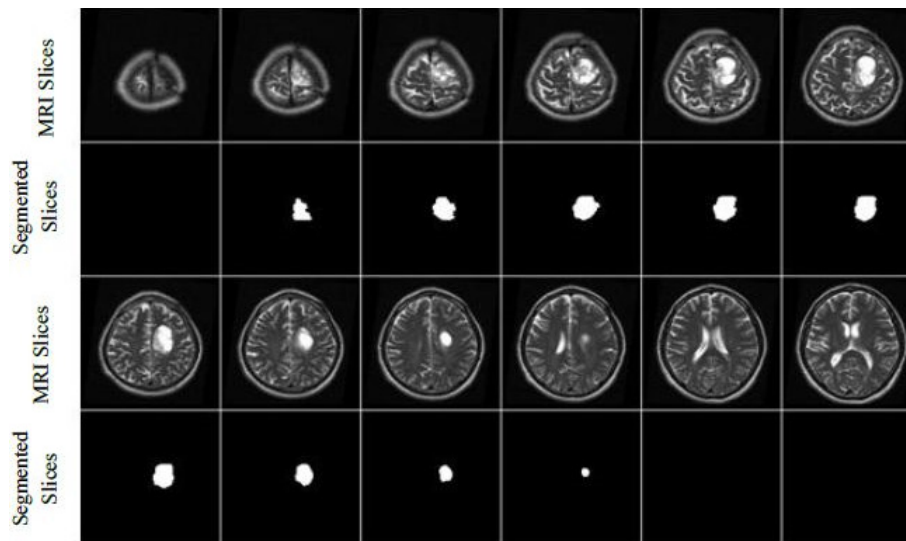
The result of segmentation of T2 weighted MRI brain slices by 3D active contour without edge segmentation method.
